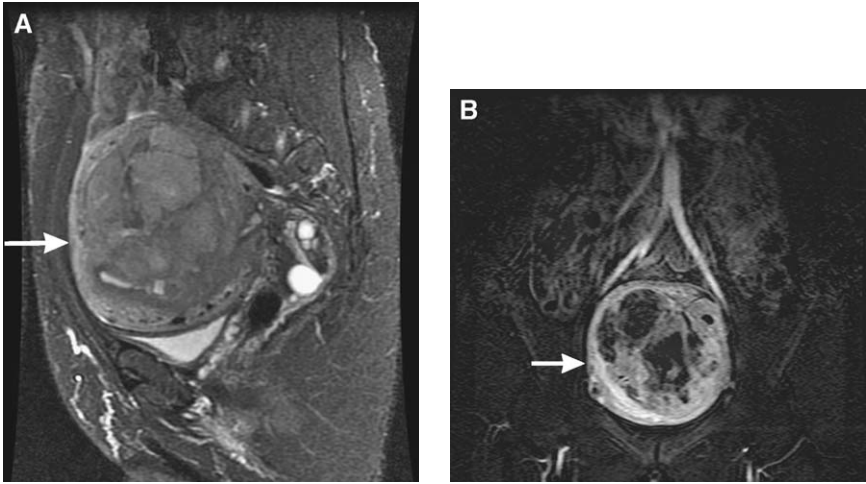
(A) A middle-aged woman who was believed to have uterine enlargement from a myoma. Sagittal T2-weighted scan shows a mass (*arrow*) primarily in the posterior wall that is heterogeneous and ill-defined. (B) Following intravenous gadolinium, coronal image shows areas of necrosis that are consistent with leiomyosarcoma.
